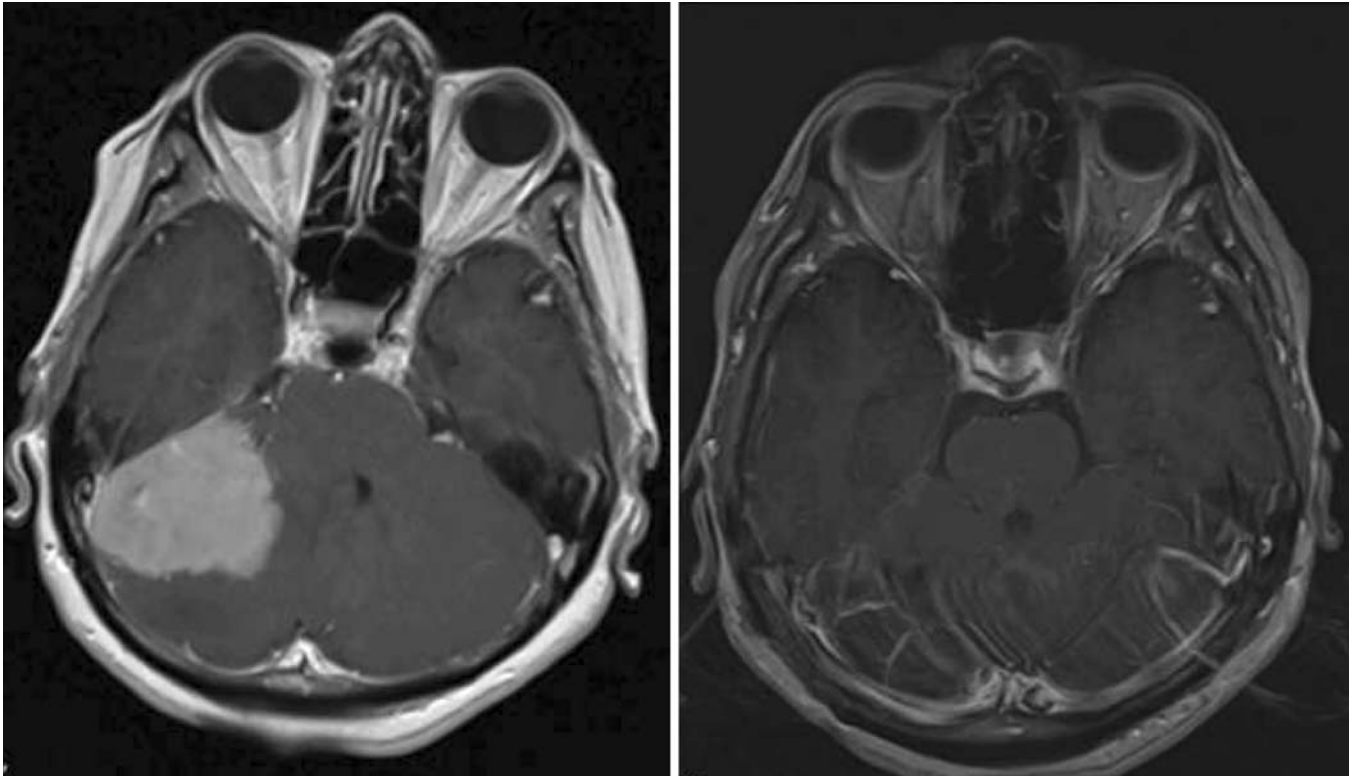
MRI brain axial post-contrast T1 weighted pre and post-operative images showing complete resection of a grade 1 meningioma arising from the tentorium cerebelli.
